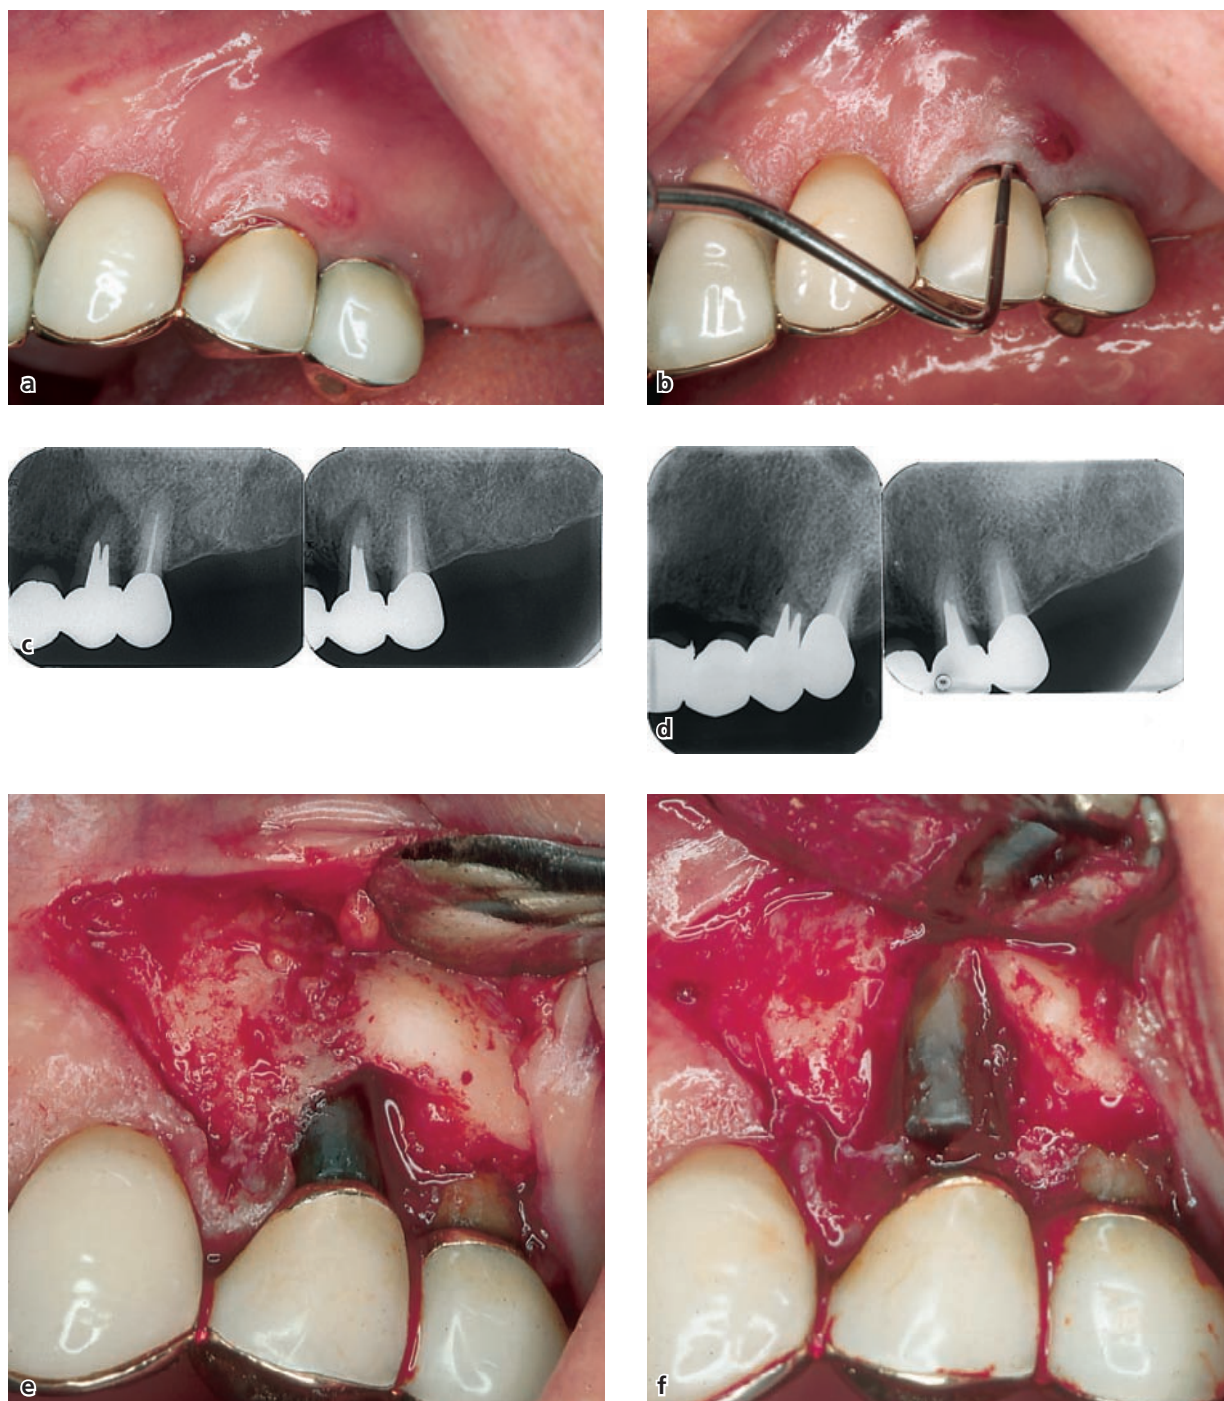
A typical case of a root fracture. (a) The first maxillary premolar had been asymptomatic for 20 years after completion of endodontic treatment and bridge-work. Patient sought treatment because of suddenly appearing pain, tenderness and facial swelling. (b) A deep periodontal pocket could be probed at the buccal aspect of the tooth, while all other sites displayed normal pocket probing depths. (c) Radiographs revealed a radiolucent area along the mesial aspect of the root system. (d) A set of radiographs taken 6 months earlier showed no such lesion. (e) Elevation of a mucoperiosteal flap revealed substantial loss of marginal bone at the buccal aspect of the root. A fracture going in a mesio-distal direction was subsequently confirmed. (f) Following removal of bone tissue, the roots were separated from the crown and extracted.
